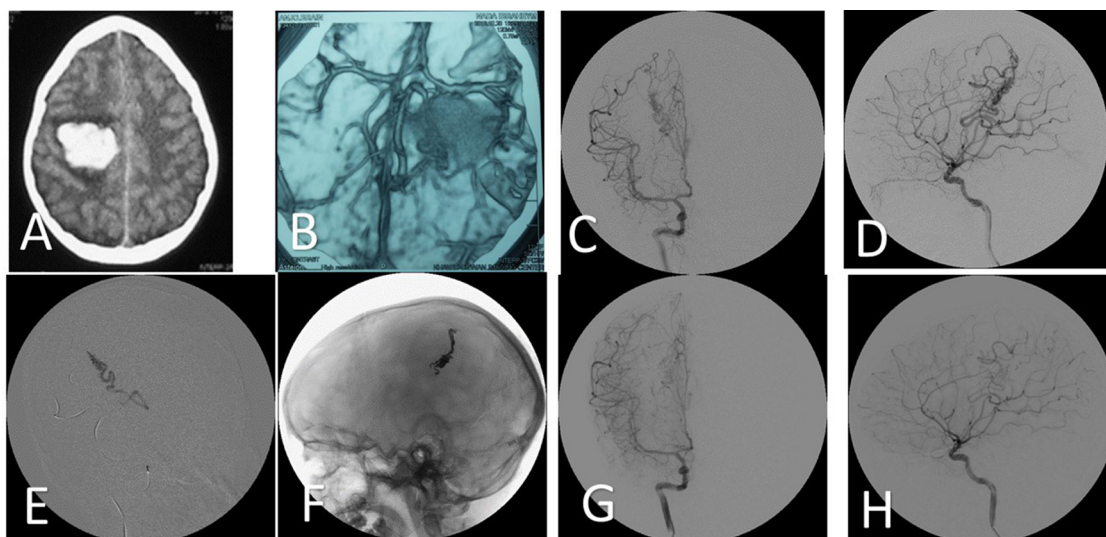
Female child, 10 years old, presented with right fronto-parietal ICH with intraventricular extension. CTA shows small Rolandic AVM. Endovascular embolization performed in one session with total obliteration of AVM. (A) Axial CT brain shows ICH (B) CTA shows small AVM and ICH (C&D) Right internal carotid artery angiogram shows AVM with feeders from Rolandic and medial lenticulostriate arteries (deep part) (E) Super selective catheterization of Rolandic artery shows nidus of AVM (F) Fluoroscopic image anteroposterior view shows Onyx cast strictly intranidal (G&H) Right internal carotid artery angiogram shows obliteration of AVM with penetration of embolic material to deeper part and foot of the vein.
